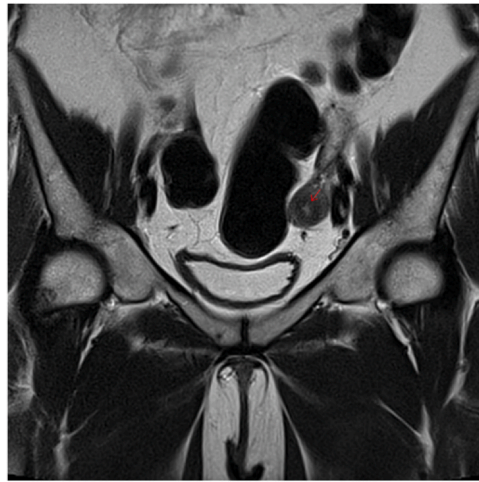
MRI image in coronal plane. The red arrow indicates uterine horn with 0.3 cm of functional endometrial tissue.
